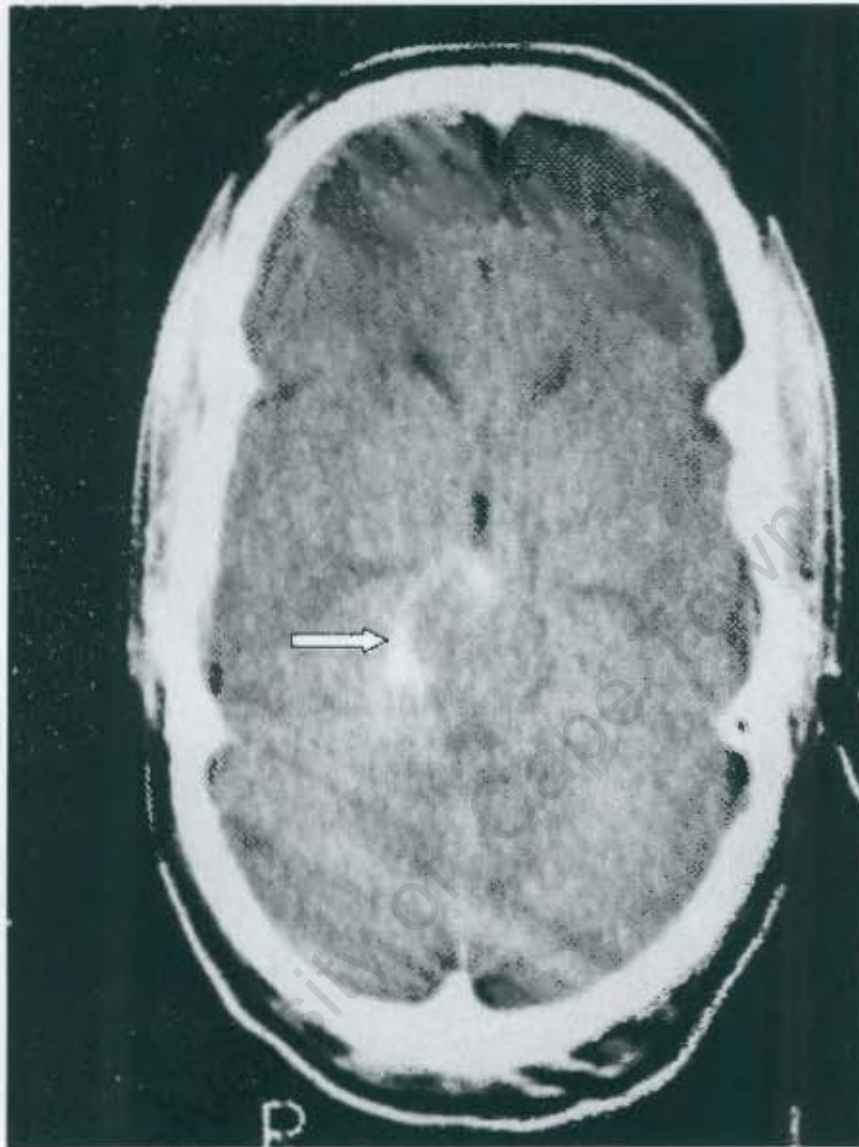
(A): Case 31. Axial CT of the brain without contrast demonstrating subarachnoid blood (white arrow) filling the prepontine and ambient wing cisterns.
